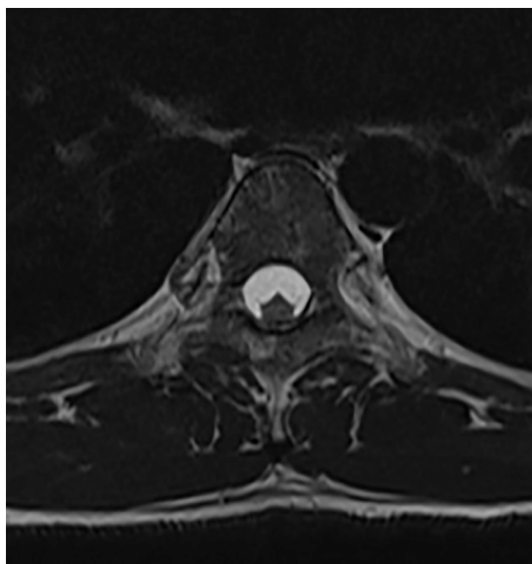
Axial section of a thoracic spinal cord MRI on T2-WI at the level of T3 showing an enlarged anterior subarachnoid space associated to a posteriorly compressed spinal cord.
